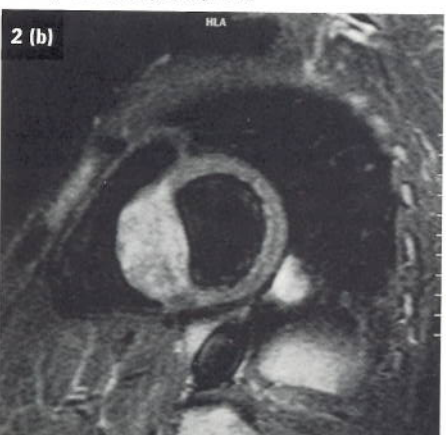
(a) For T2-weighting, the data acquisition will be triggered on every second or third R-wave to result in a longer TR. T2-weighted TSE visualizes metastatic tumor in ventricular septum. (b) Turbo STIR technique is helpful to show edema or inflammation. (Courtesy of Cleveland Clinic, Cleveland, Ohio, USA)
